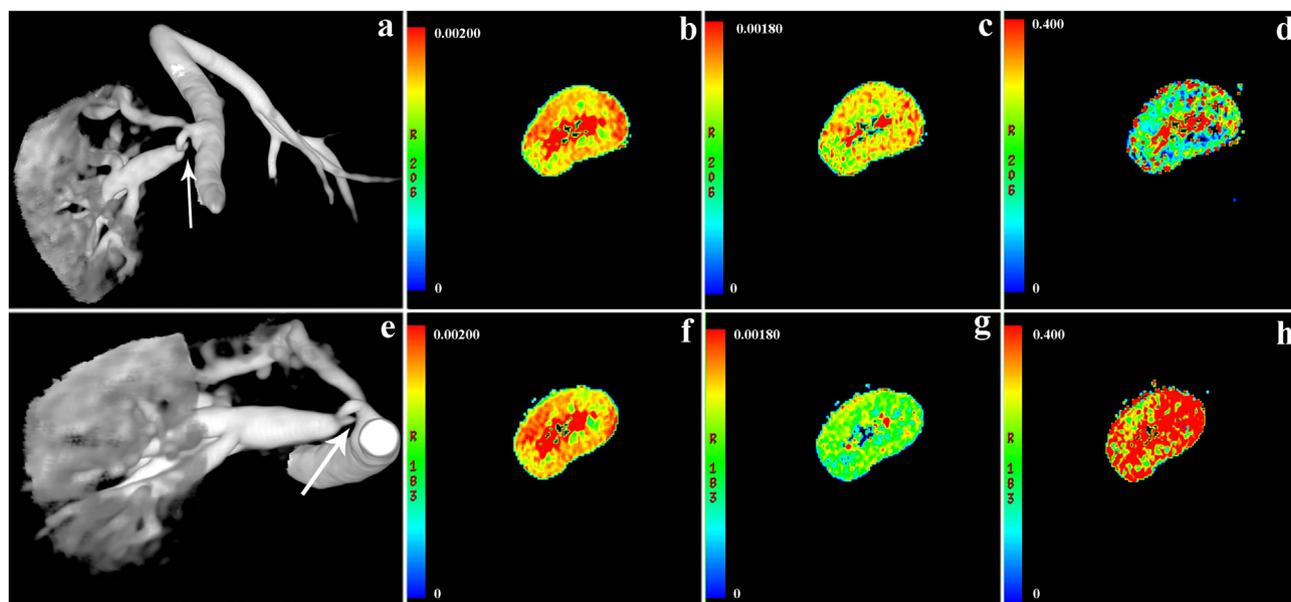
Non-contrast enhanced magnetic resonance angiography and DWI images of the patient before and after unsuccessful angioplasty. a: Maximal intensity projection before angioplasty showed severe TRAS (arrow). b–d: ADC_T , D and Fp of this patient before angioplasty. e: After angioplasty, maximal intensity projection of non-contrast magnetic resonance angiography revealed still severe TRAS (arrow). f–h: ADC_T , D and Fp of this patient after angioplasty.
